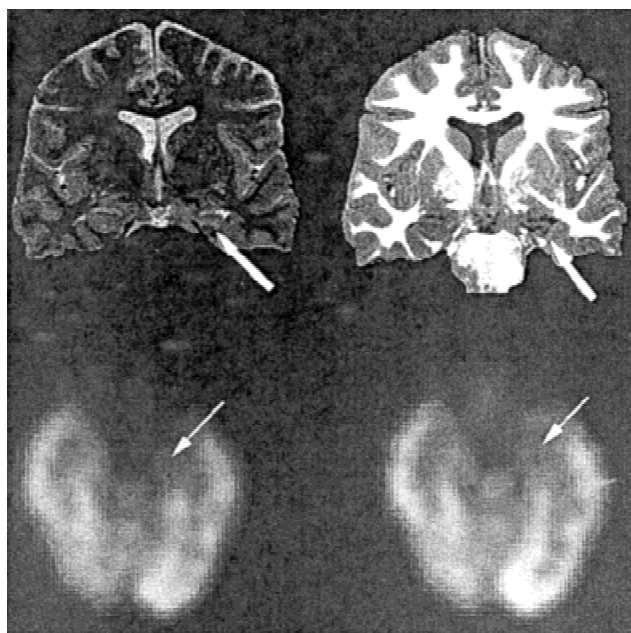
Left hippocampal sclerosis (arrows) demonstrated by T2-weighted images (top, left) and an inversion recovery sequence (top, right) and decreased glucose metabolism in the left mesial temporal region (arrows) seen on PET (bottom) in K.G.
